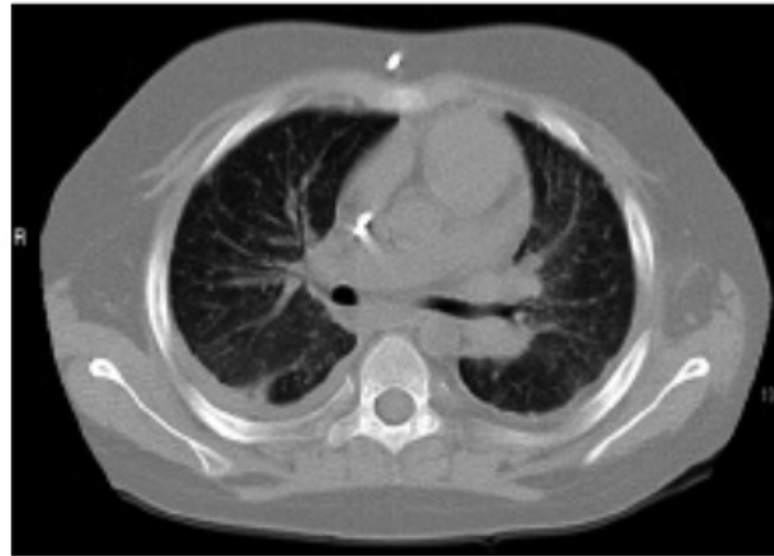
Chest CT: diffuse reticulo-micro-nodular parenchymal pattern, with increased lymphadenopathies mainly in the left hilum; a bilateral pleural effusion is also present.
